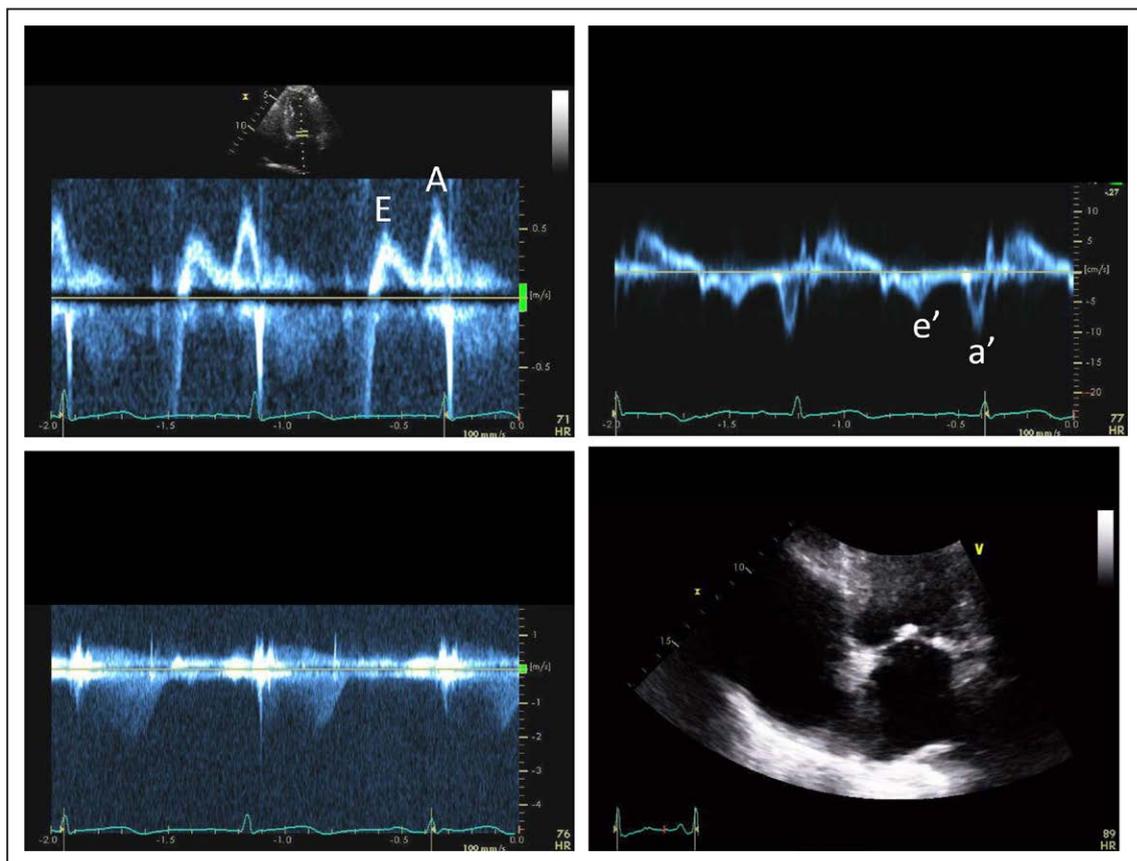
Mitral inflow (upper left), lateral tissue Doppler (TD) velocities (upper right), tricuspid regurgitation velocity by continuous-wave Doppler (lower left), and zoomed view for the left atrium in apical 4-chamber view (lower right) from a patient with hyperdynamic LVEF.
